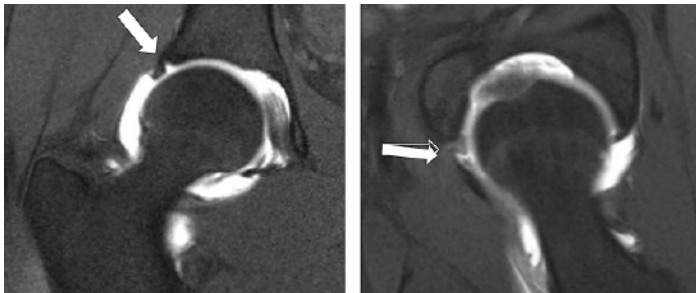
T1-weighted coronal (left) and axial (right) MR images of the right hip showing the superior labral tear (solid white arrow).
